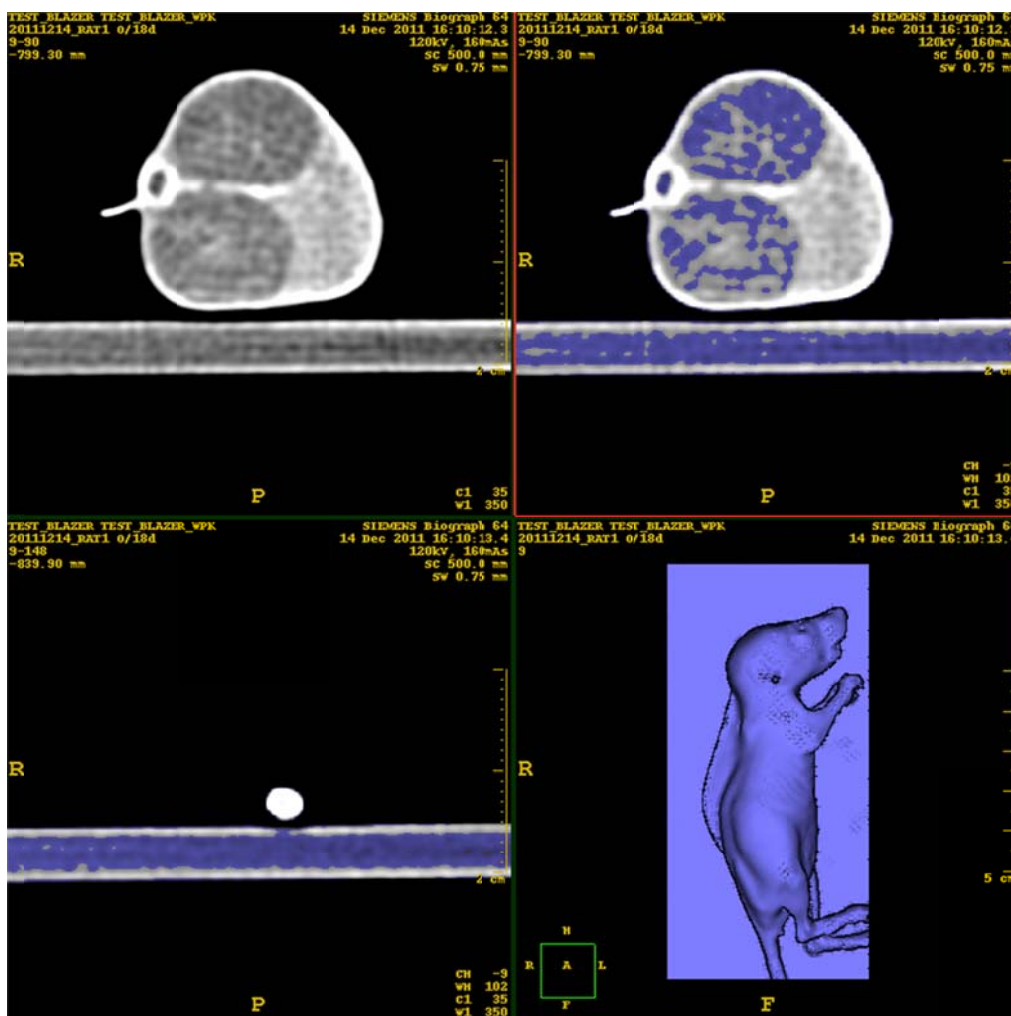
18 Day Pioglitazone 2-D Image of CT values labeling for cystic tissue from Philips program
